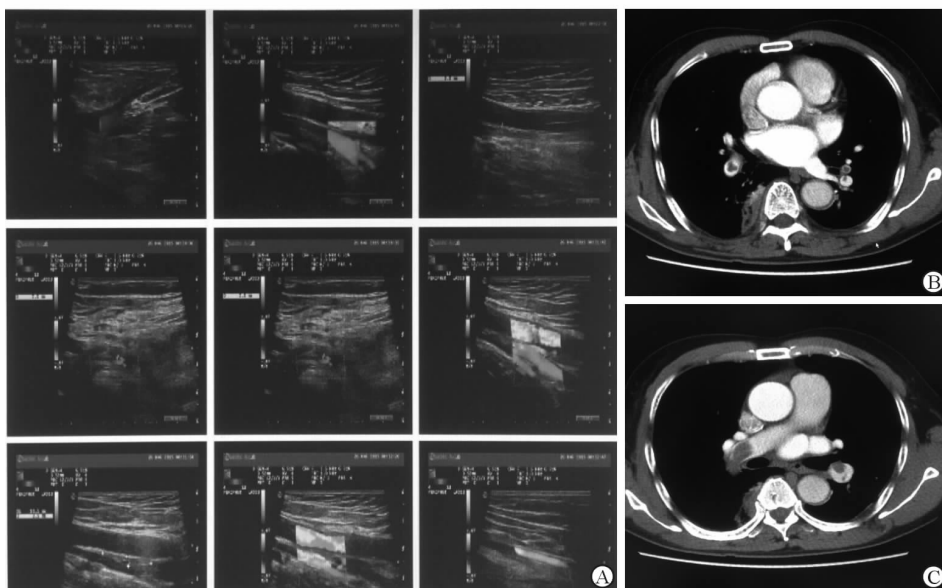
右股骨粗隆间骨折内固定术后患者下肢 B 超及肺动脉 CTA 图像
